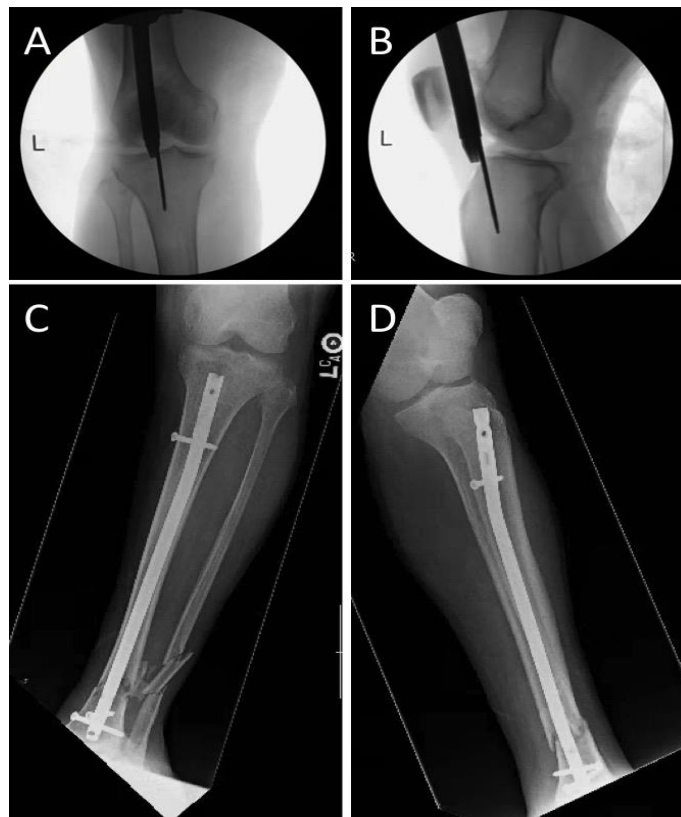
Intraoperative fluoroscopy with AP (A) and lateral (B) views of knee demonstrating starting point for intramedullary nail achieved using suprapatellar approach. AP (C) and lateral (D) X-rays of tibia after intramedullary nailing.
